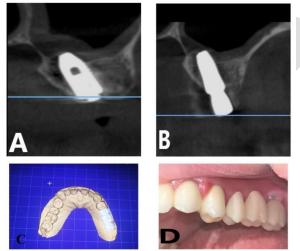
X-ray done immediate post operative. B) X-ray 6 months follow up. C) Digitally designed crowns.D) Final crowns delivery.Edema and nasal bleeding
